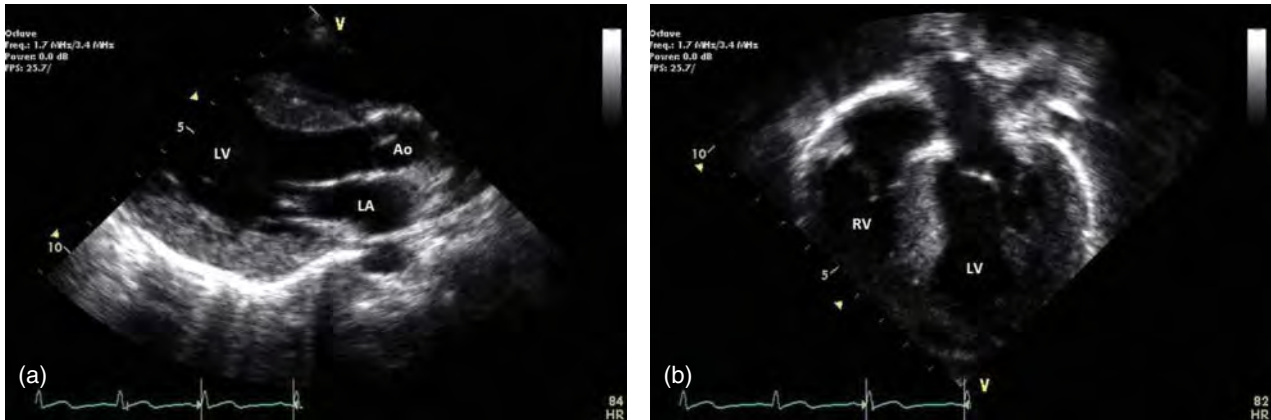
Echocardiograms of Pompe disease with left ventricular hypertrophy. (a) Parasternal long-axis and (b) apical four-chamber view of patient with Pompe disease with concomitant LV hypertrophy demonstrating concentric hypertrophy; maximum septal wall thickness 23 mm.
